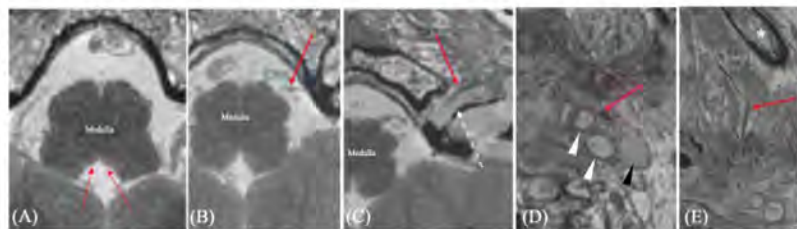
Axially reformatted CISS MRI of segments of CN XII (red arrow) (A) Hypoglossal trigone (dotted red arrow) (B) Cisternal segment (C) Foraminal segment (CN XII inside the hypoglossal canal) (D) Extra-foraminal-carotid space segment (E) Extra-foraminal-anterior segment. \*: mandible; hypoglossal canal (white dashed arrow); left internal and external carotid arteries (white arrowheads); left internal jugular vein (black arrowhead)
